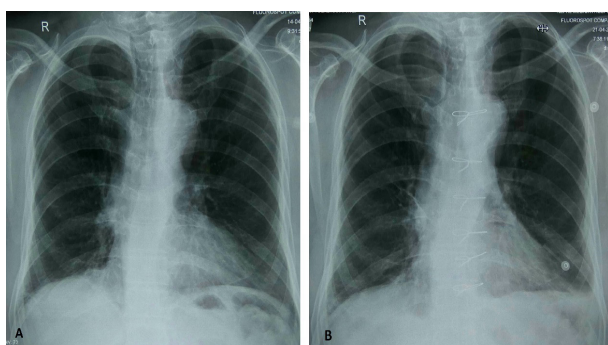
Preoperative (A) and Postoperative Chest X-ray (posterior-anterior view) on 6th postoperative day (B).
